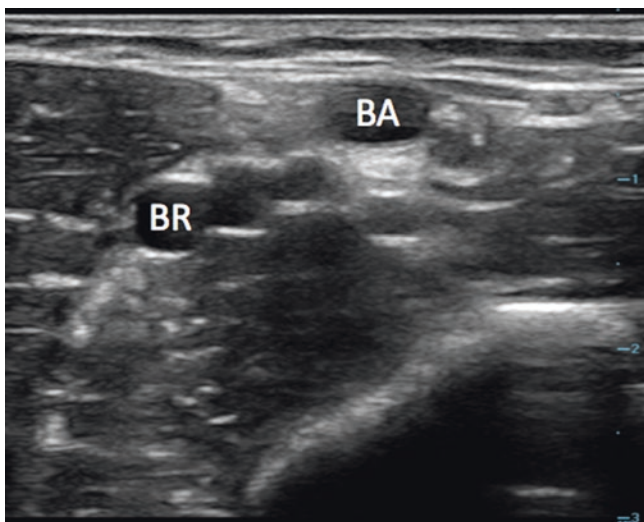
Ultrasound image of the right medial upper arm. The basilic (BA) and deep brachial veins (BR) can be visualized in this region. Image courtesy of Stephen Alerhand
